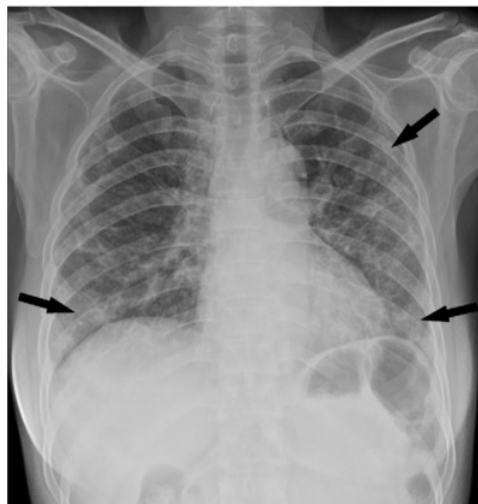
Chest radiograph of a 53 year old female patient with confirmed COVID-19 pneumonia
